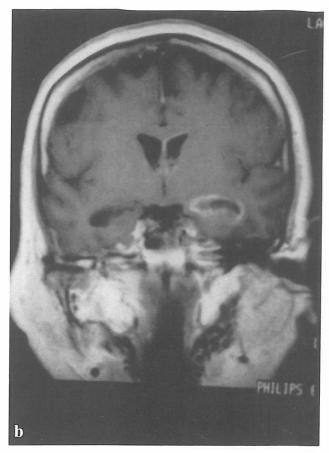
(a-b): Primary CNS lymphoma; axial (a) and coronal (b) post-contrast T1 weighted MRI shows periventicular lesions with venticular wall involvement.
